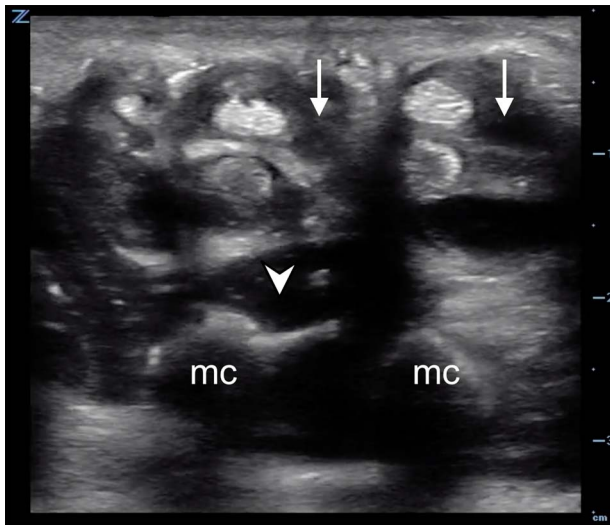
In this transverse ultrasound view of the patient's left palm, complex fluid (white arrows) is seen within the synovial sheath surrounding the paired flexor tendons. Also note the hypochoic fluid in the midpalmar space (arrowhead) superficial to the metacarpals (mc).
